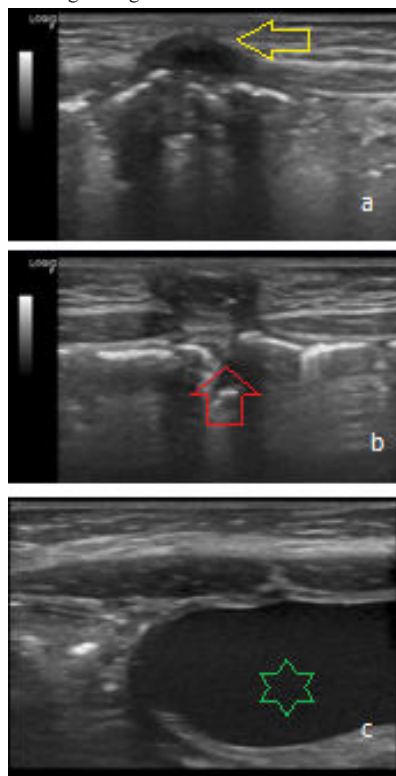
Ultrasonography images (USG) in transverse plain with 7.5 MHz linear probe. a) hypo- to anechoic midline bulge seen in the umbilical region at the site of abdominal wall defect (yellow arrow). b) clear abnormality is visualised in slightly deeper plane (red arrow). c) dilated loop is seen still in deeper plane in the abdomen (green star).
